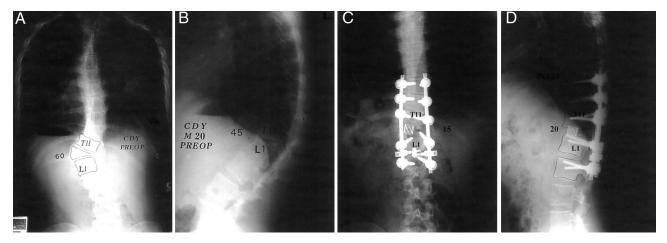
(A and B) A 20-year-old man with a congenital hemivertebra T12. The magnitude of coronal and sagittal angle was 60° and 45°, respectively. Trunk was 2.5 cm shifted to the left. Lateral roentgenogram show marked hyperkyphosis at thoracolumbar area. (C and D) Postoperative 2-year follow-up standing radiographs. The coronal and sagittal angle was corrected to 15° and 22°, respectively. He was balanced with same shoulder heights. Preoperative thoracolumbar hyperkyphosis was satisfactorily improved.
